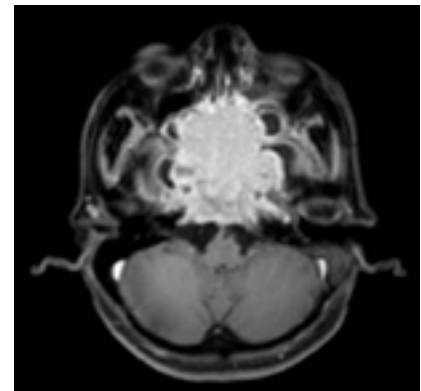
MRI (T1) contrast axial – isointense enhancing sphenoid sinus mass lesion causing erosion of walls of sphenoid, clivus with infiltration of cavernous sinus and encasement of internal carotid arteries
